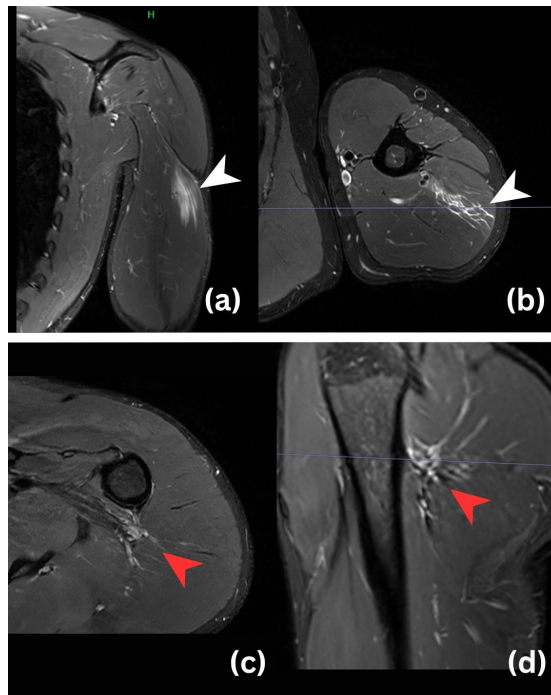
MRI of left humerus. (a) Coronal view of MRI humerus showing lateral triceps oedema (white arrow), corresponded to the axial view of MRI (b). (c) Axial view and (d) sagittal view showed no space occupying lesion or compression over radial nerve at triangular interval at left shoulder (red arrow)
